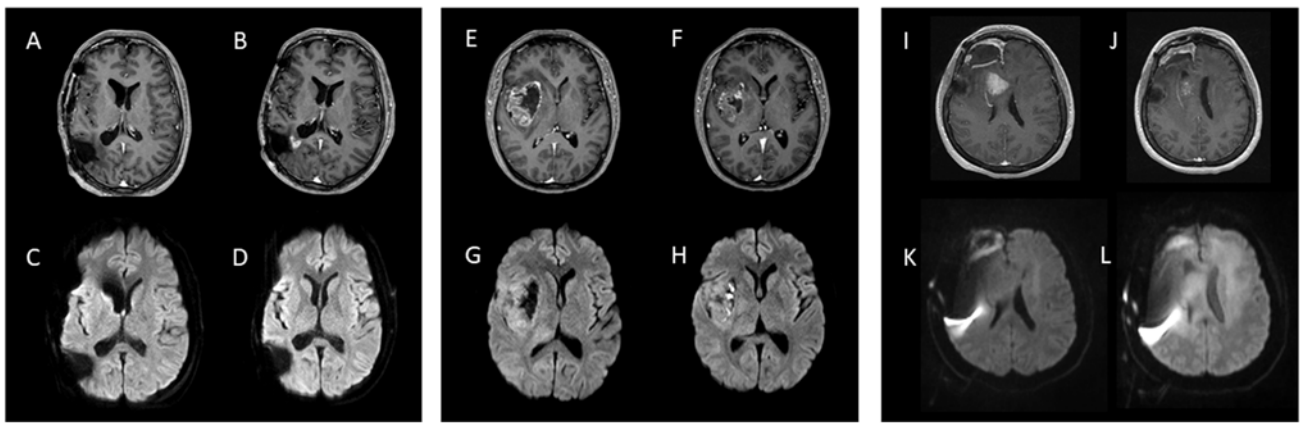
Patients of the cohort without marked diffusion restriction. (A-D) Patient 2: Post-contrast T1-WI MRI (A) before and (B) after FTM treatment; DWI b1000 maps (C) before and (D) after FTM treatment. (E-H) Patient 7: Post-contrast T1-WI MRI (E) before and (F) after FTM treatment; DWI b1000 maps (G) before and (H) after FTM treatment. (I-L) Patient 14: Post-contrast T1-WI MRI (I) before and (J) after FTM treatment; DWI b1000 maps (K) before and (L) after FTM treatment. T1-WI MRI, T1-weighted magnetic resonance imaging; DWI, diffusion-weighted imaging; FTM, fotemustine.
